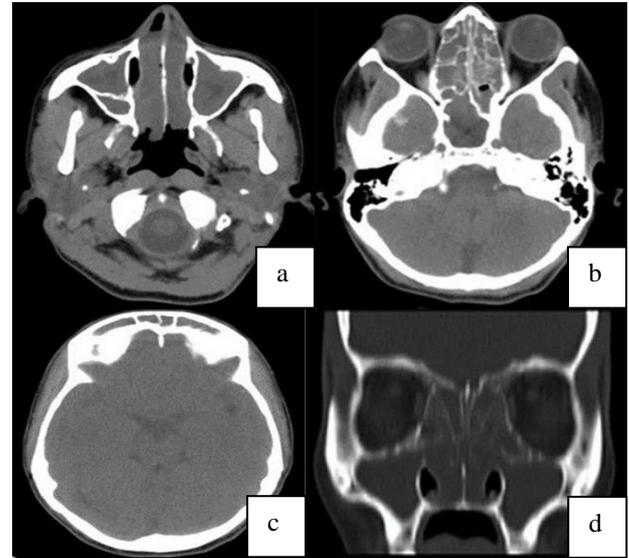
Axial (a, b, c) and coronal (d) CT images showing gross mucosal thickening in bilateral frontal, maxillary, ethmoid and sphenoid sinuses and nasal cavity. Bilateral pan sinusitis with bilateral osteomeatal unit obstruction and spheno ethmoidal recess pattern of inflammation. Bony septum is seen in right maxillary sinus.
